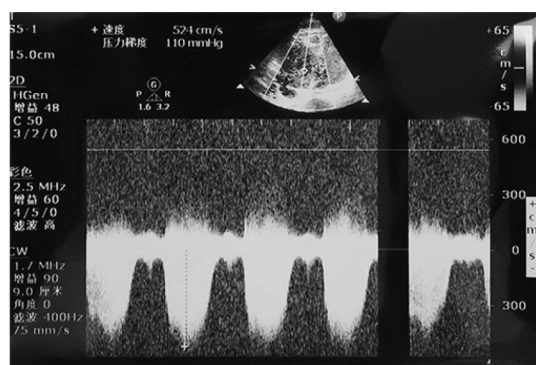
Two-dimensional transthoracic echocardiogram at terminal stage showing severe tricuspid regurgitation with a pulmonary artery systolic pressure of 125 mmHg.
